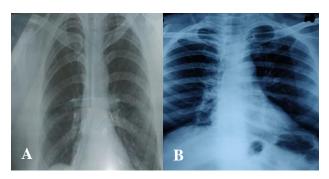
(A) Pre-operative X-ray showing endodontic file, (B) post-operative chest X-ray.
